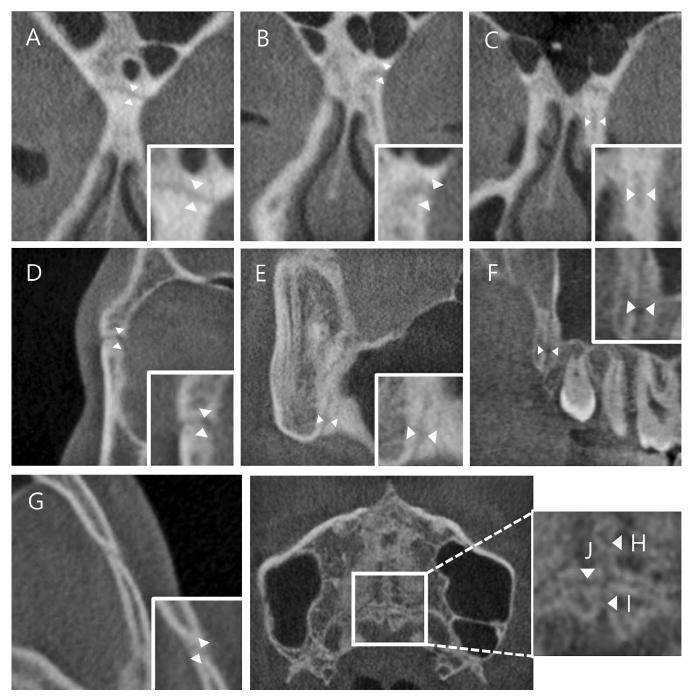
Sections of CBCT images showing the width of circummaxillary sutures. (A–E) Coronal sections: (A) Frontonasal; (B) Frontomaxillary; (C) Nasomaxillary; (D) Frontozygomatic; (E) Zygomaticomaxillary; (F) Pterygomaxillary, sagittal section. (G–J) Axial sections: (G) Zygomaticotemporal; (H) Midpalatal; (I) Interpalatine; (J) Transverse palatine. The arrows indicate the bony edges of the suture that show the greatest width.
